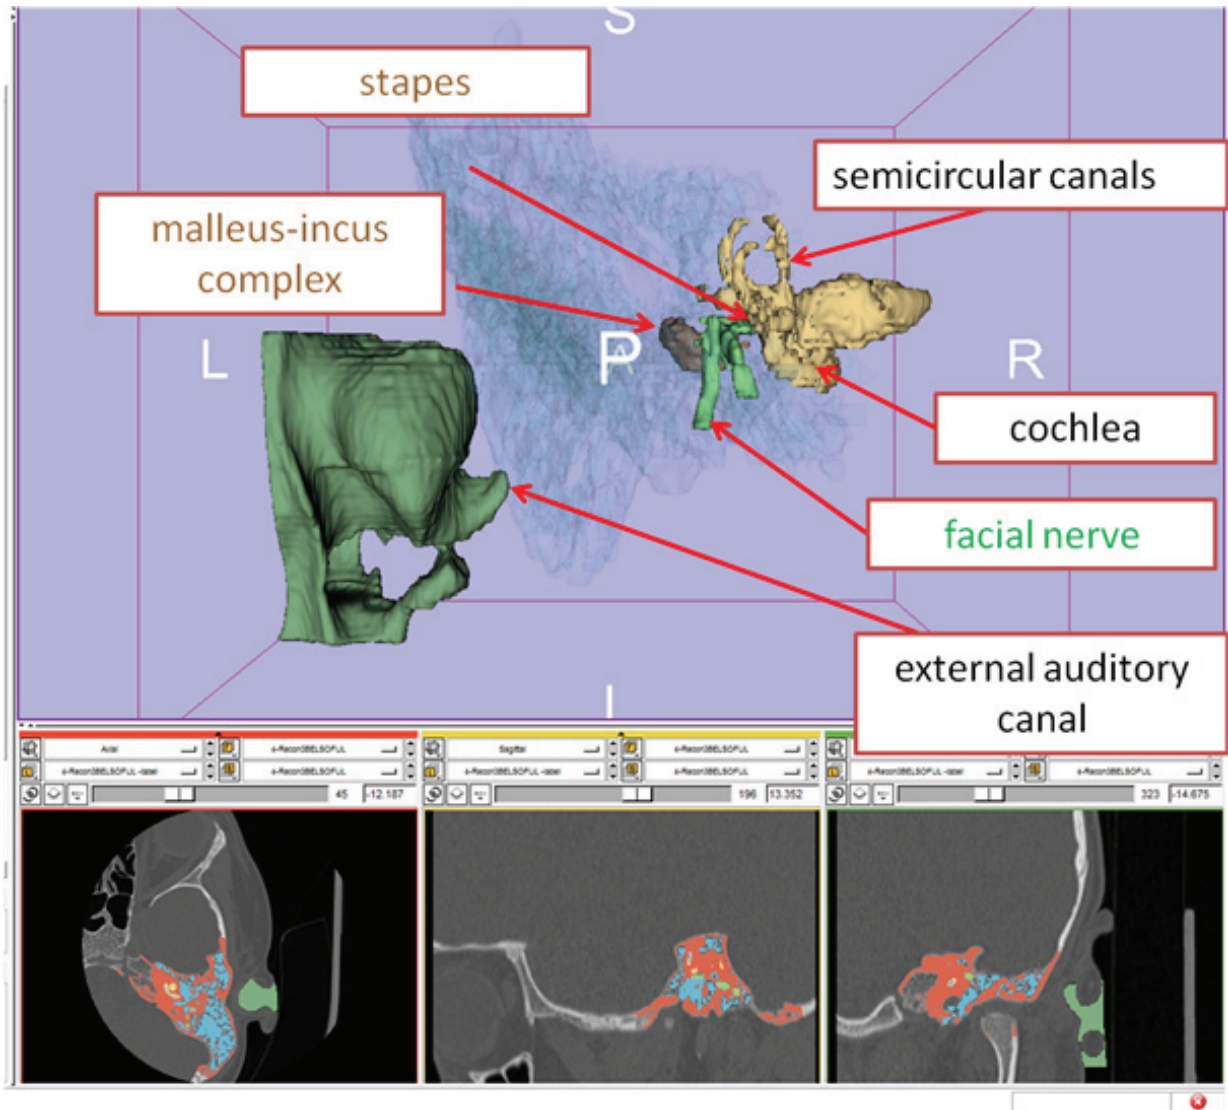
Three dimensional CT reconstruction of the external, middle, and inner ear of the ear with external auditory canal atresia. 3D Slicer 4.3.
